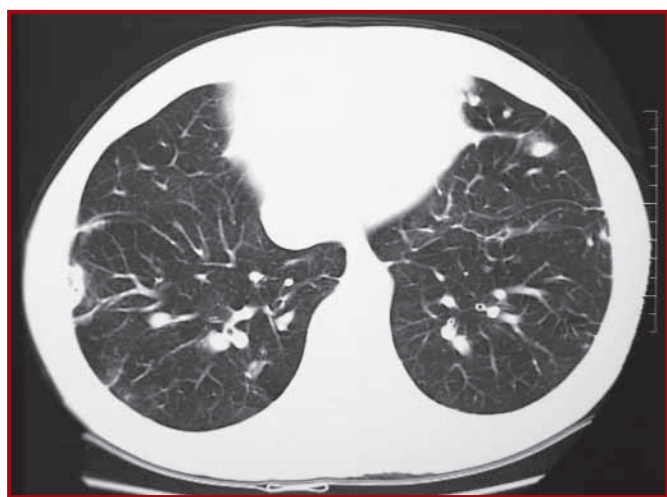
Computed tomography showed bilateral pulmonary multinodular lesions
